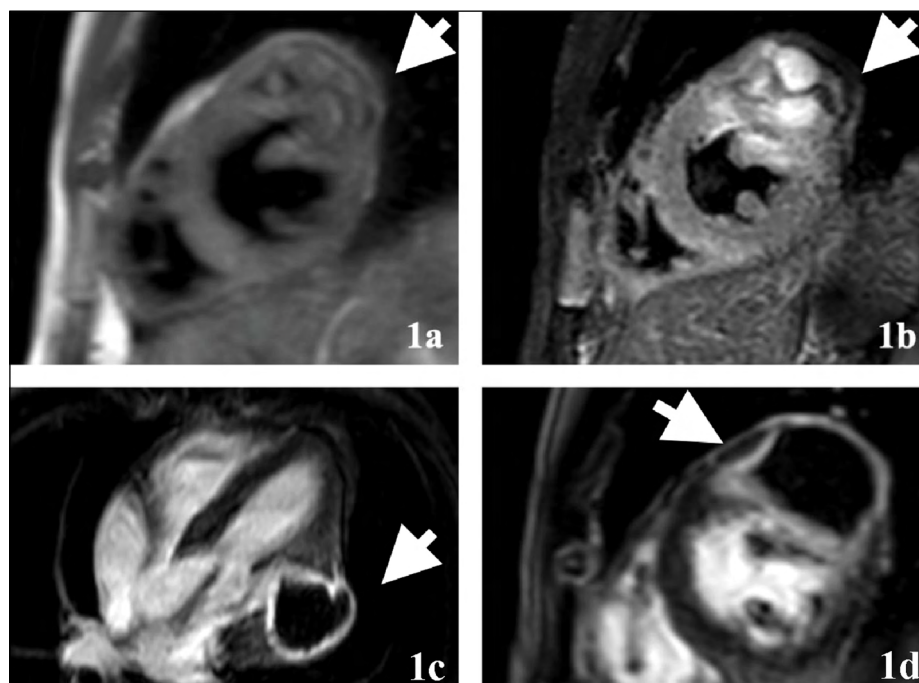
Multicystic lesion in the lateral left ventricular wall: morphology and late gadolinium enhancement findings. (1a) Short-axis double inversion recovery dark blood image at basal to mid-cavity level; (1b) short-axis T2-weighted short-tau inversion recovery image at the basal to mid-cavity level. A multicystic structure is noted with thick septations and fluid-filled cystic structures in the basal-mid lateral/ anterolateral segment of the left ventricle bulging outwards towards the pericardial margin as well as mildly towards the cavity. Mild cyst wall enhancement noted on the late gadolinium enhancement (LGE) imaging; (1c) 4-chamber phase-sensitive inversion recovery (PSIR) LGE and (1d) short-axis PSIR LGE.
